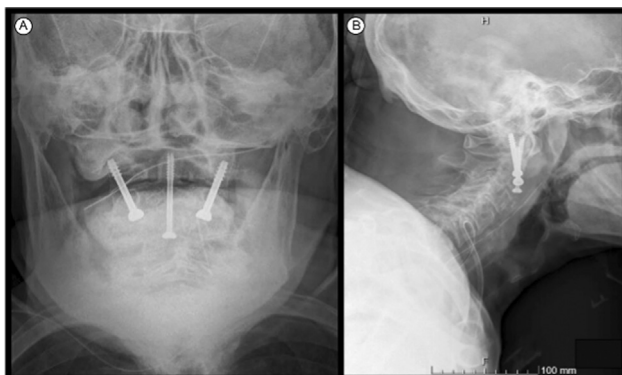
Radiograph of the cervical spine on AP (A) and lateral (B) incidences.
